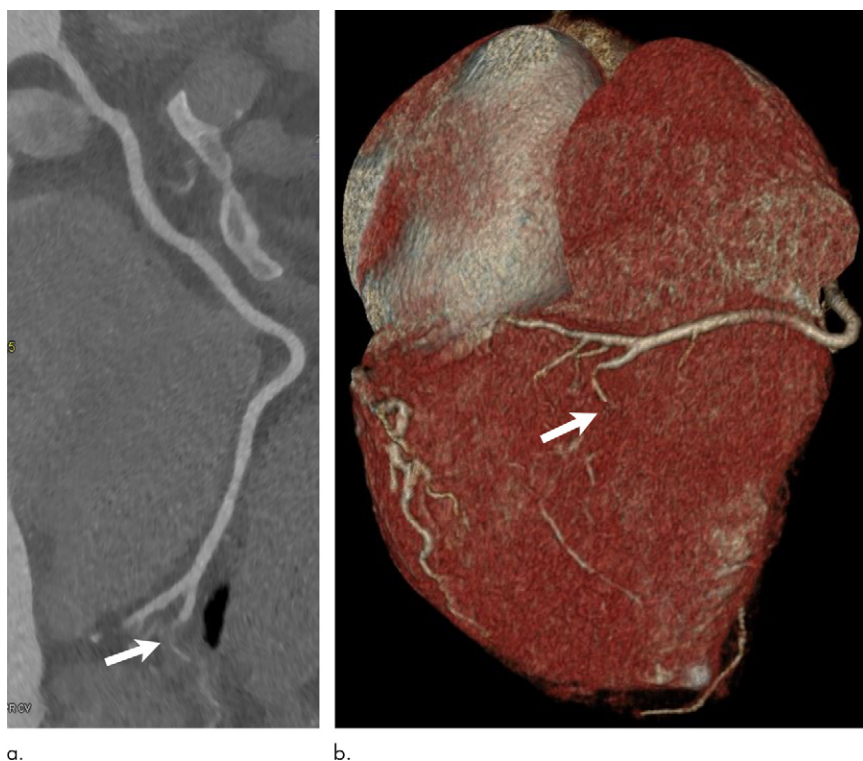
(a) Curved planar reformatted and (b) volume-rendered three-dimensional coronary CT angiography images in a 42-year-old woman with prior history of apical infarct, who presented to emergency department with chest pain, show irregular tapered severe narrowing of the proximal posterior descending artery with adjacent epicardial fat stranding (arrow).
